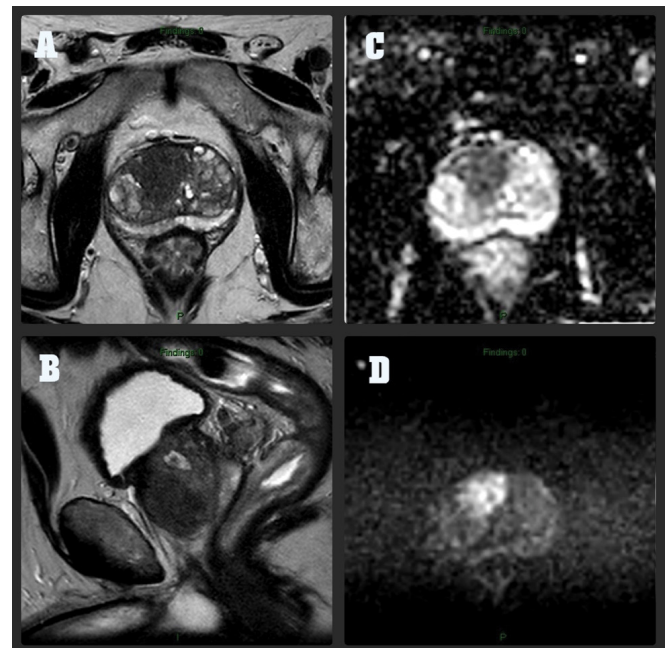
Magnetic resonance imaging protocol for primary prostate cancer localization. (A,B) A T2 low signal intensity focus was noted at right anterior-posterior part of right peripheral zone, with dimensions of 3.1cm, 3.4 cm axial & sagittal plane respectively. the possibility of extracapsular extension was excluded. (C,D) The lesion showed hyperintense on high b-value DWI and hypointense on ADC, DWI & ADC plane respectively.
